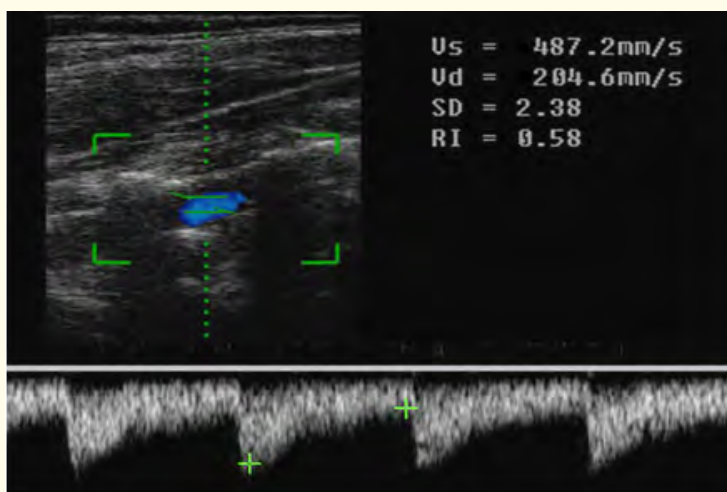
Doppler spectrum of the blood flow in second segment of the vertebral artery in neutral position of patient. Vs is 48,7 cm/c, RI - 0,58.
